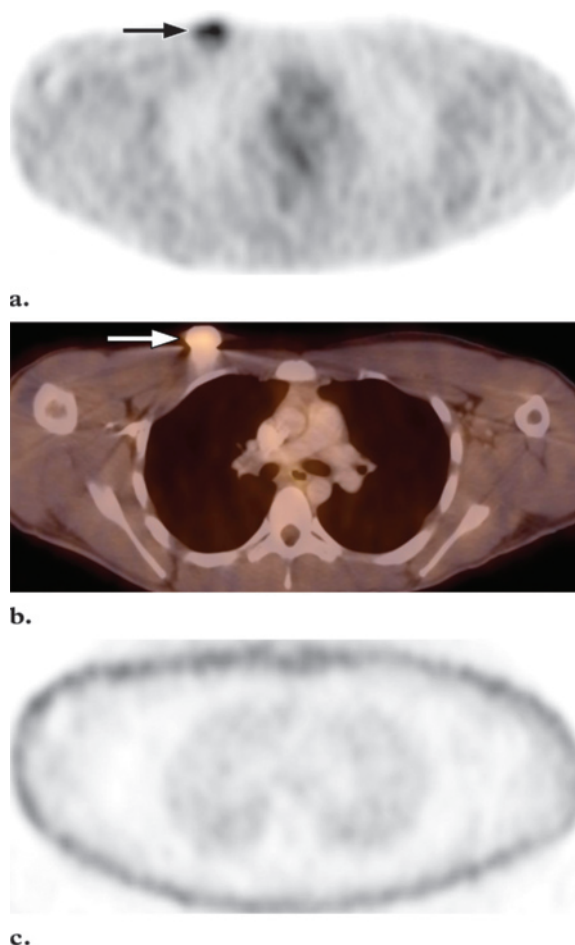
Attenuation correction artifact. (a) Transverse attenuation-corrected FDG PET scan shows a focus of increased uptake in the upper right chest wall (arrow). (b) Transverse fused PET/CT image also shows the focus of increased uptake (arrow), a finding that represents a catheter. (c) Transverse non-attenuation-corrected FDG PET scan shows no increased uptake. The high attenuation of a catheter leads to overcorrection of the activity on attenuation-corrected images. This artifact is not present on non-attenuation-corrected images.
